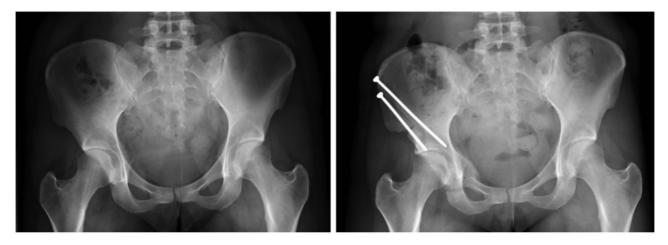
Pre- and post-operative X-rays of one of the operated patients. Note that on the pre-operative X-ray of the right hip there is crossover, posterior wall sign and ischial spine sign. On the post-operative X-ray of the same hip, there is no longer crossover and posterior wall sign.
